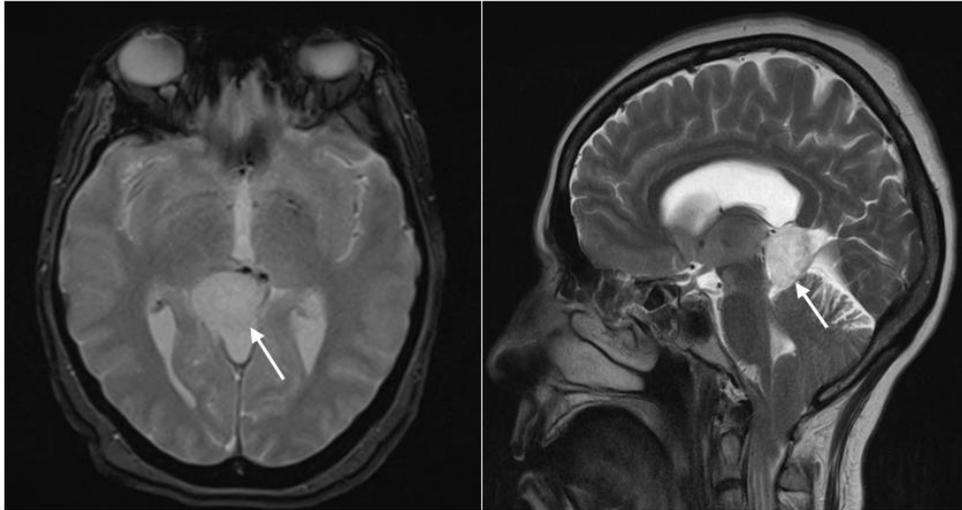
Axial and sagittal enhanced T2-weighted MR image: Median process of the pineal region, rounded in shape, well limited, appearing hyperintense on T2
